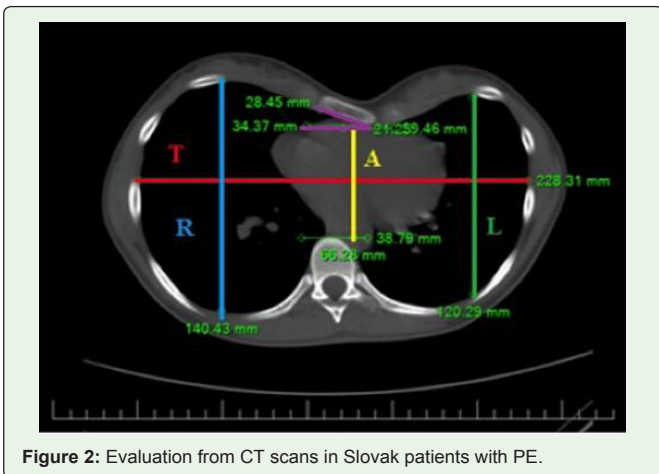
Evaluation from CT scans in Slovak patients with PE.
